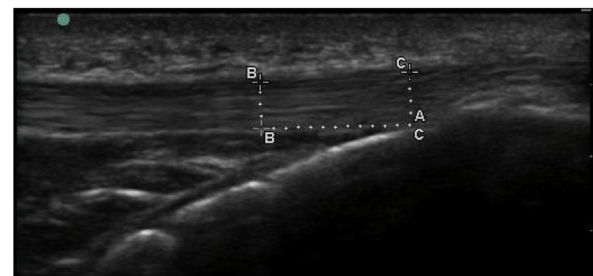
Sonographic image of measurement site (TT & 1uTT).
